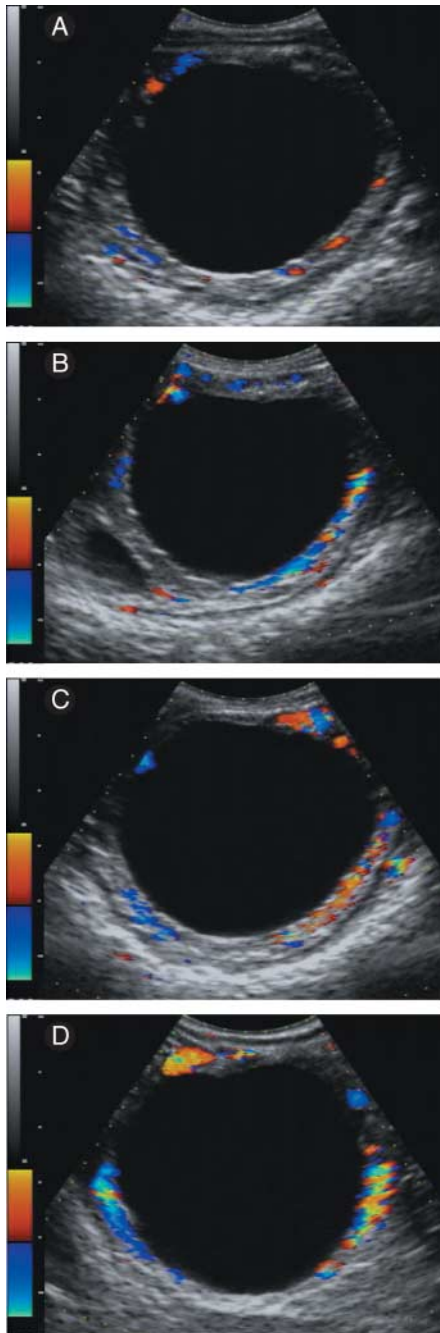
Sequential colour-Doppler ultrasonograms of preovulatory follicles of a control mare at 36 (A), 38 (B), 44 (C) and 60 h (D) after the largest follicle reached ≥ 35 mm (hour 0, treatment time). Ovulation was detected at hour 84. Note the increase in colour-Doppler signals (amount of colour dots and intensity) as the follicle matured (top to bottom). Most of the colour-Doppler signals are located within or extend beyond the width of the anechoic band of the follicle wall. Distance between graduation marks (left) is 1 cm.
